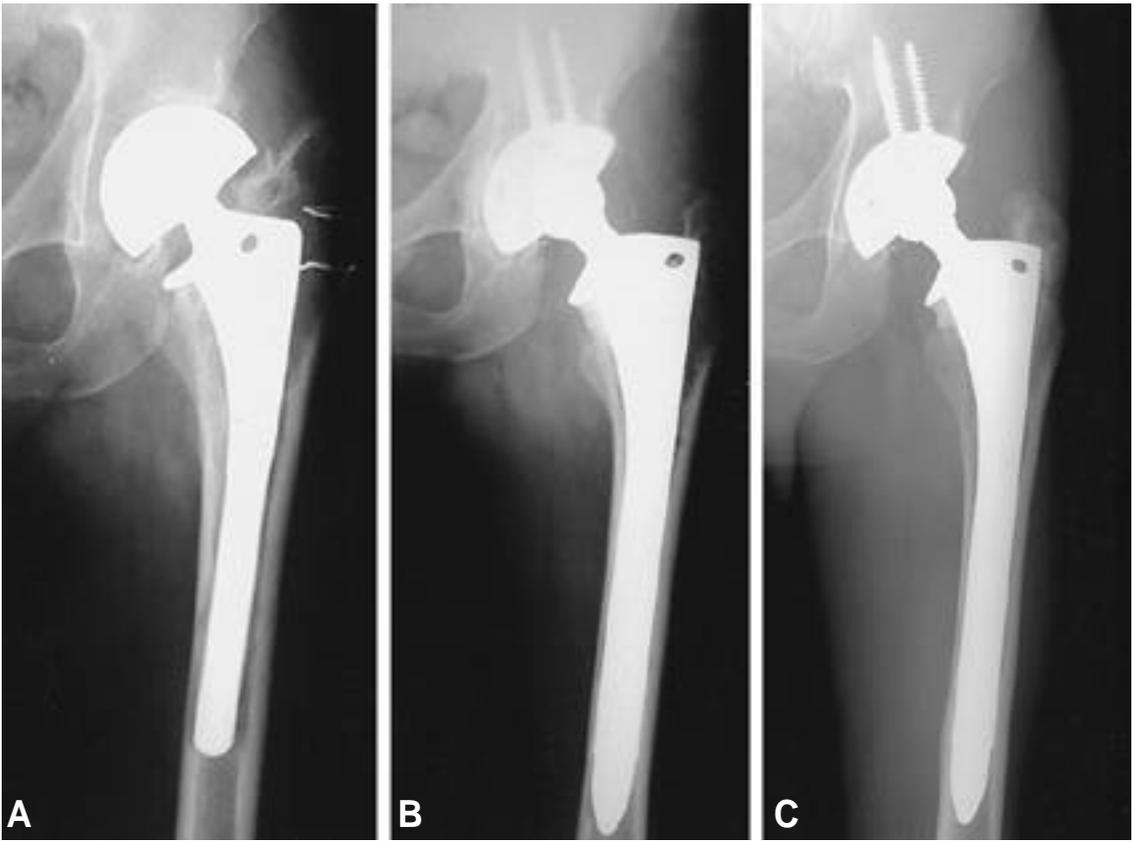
(A) Preoperative radiograph shows diffuse osteolysis around the femoral stem. (B) Postoperative radiograph reveals an excellent fixation of the stem with bypassing the osteolytic lesion. (C) Postoperative 4 years radiograph show a healing of the osteolytic lesion.
